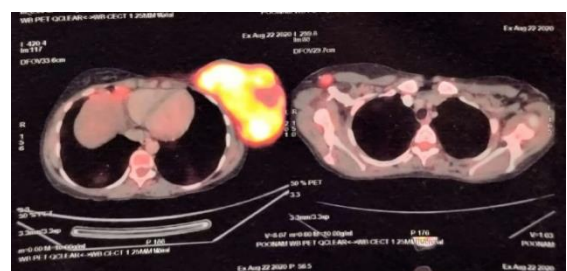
PET scan showing large mass (13 × 10 cm) with high FDG avidity (SUVmax 14.0) in left breast
